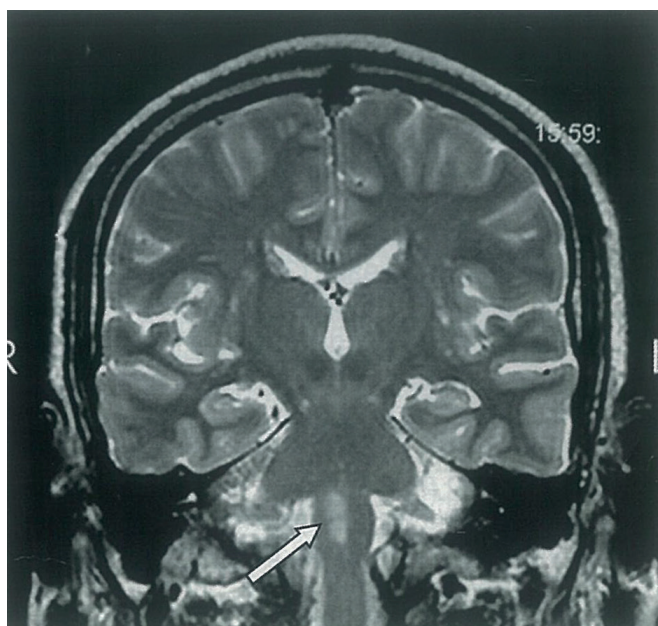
DWI MRI imaging of the brain of patient O., 56 years old was performed 36 hours after the onset
